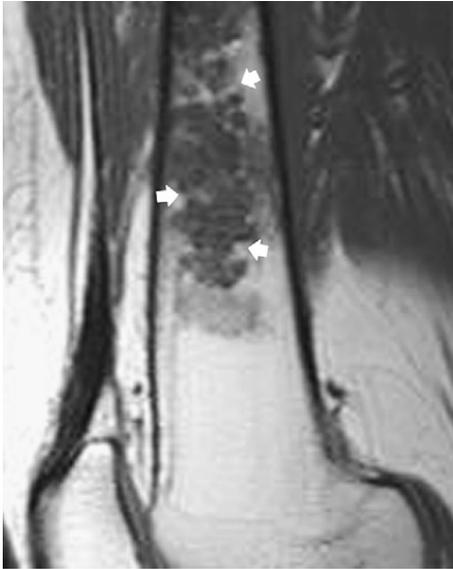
Incidentally noted chondrosarcoma in a 53-year-old man. Sagittal T1-weighted (TR/TE; 491/13) spin-echo MR image shows a large cartilage tumor. The characteristic lobular contour and interdigitating marrow fat (*arrows*) are well seen. The lesion extended to the lesser trochanter, and features of malignancy were seen in the proximal aspects of the mass.
